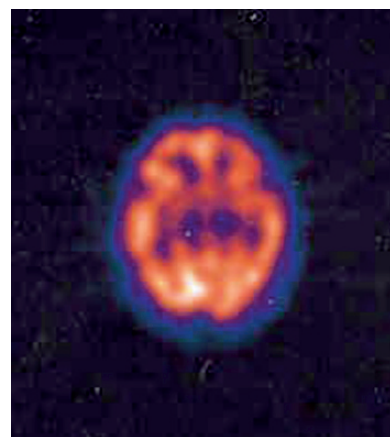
Normal SPECT scan (see Color Plate 6, following p. 650).
